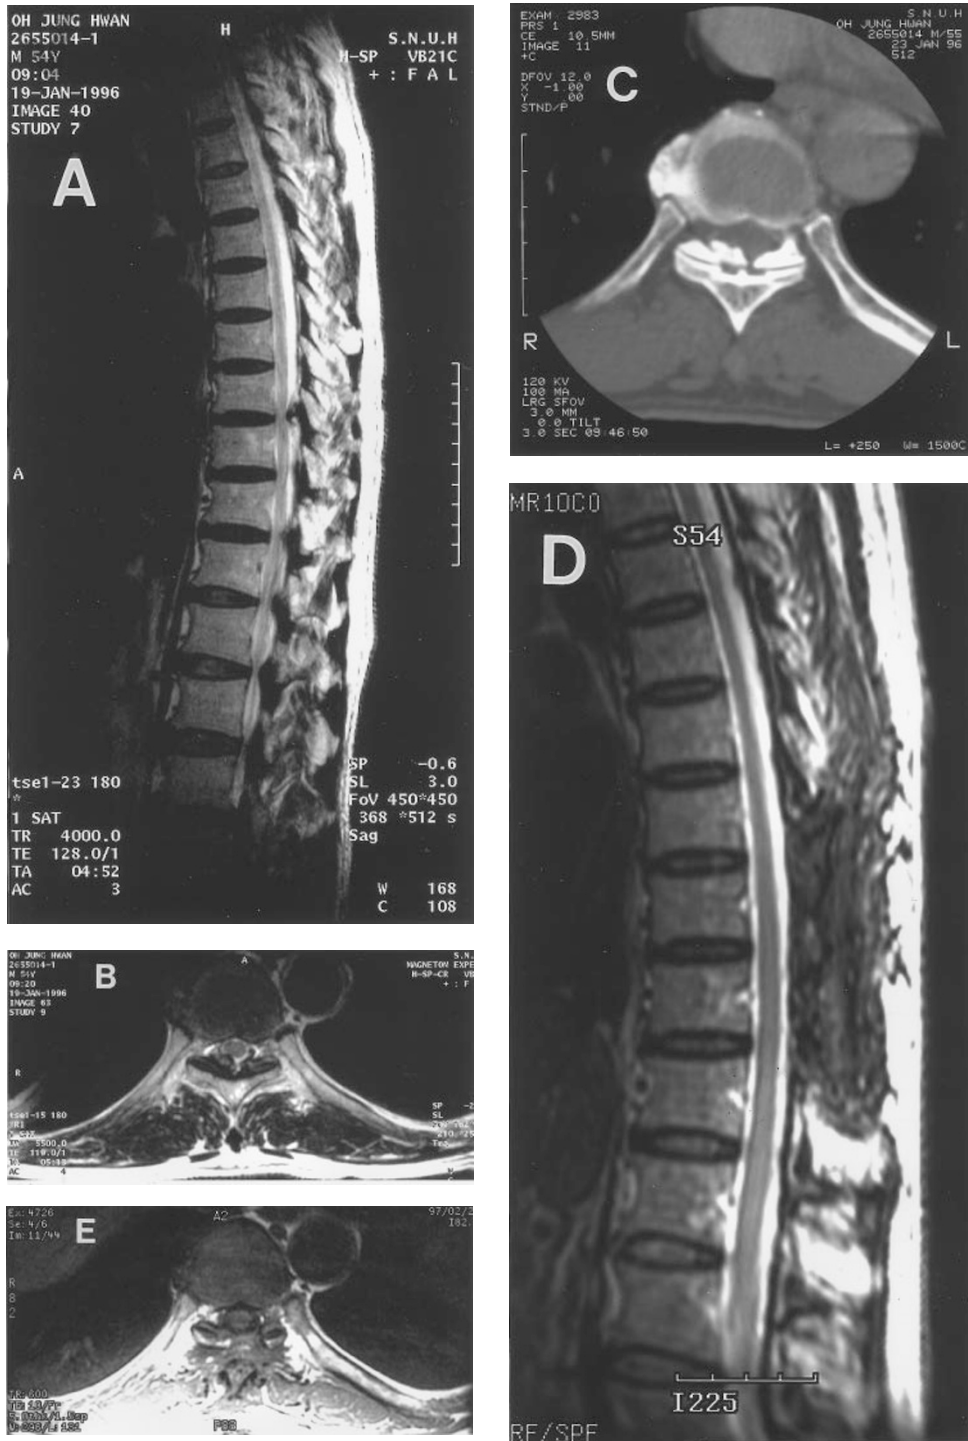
A 55 year-old man presented with progressing paraparesis and tingling sense of his legs. T2-weighted sagittal (A), axial (B) magnetic resonance (MR) image and computed tomography (C) showed thoracic stenosis due to ossification of ligamentum flavum in T9–10 level. Decompression through posterior approach was done. Follow-up MR images after 12 months after operation demonstrate restoration of cerebrospinal fluid space on T2-weighted sagittal (D) and T1-weighted axial (E) image. His neurological problem gradually improved during the follow-up period
